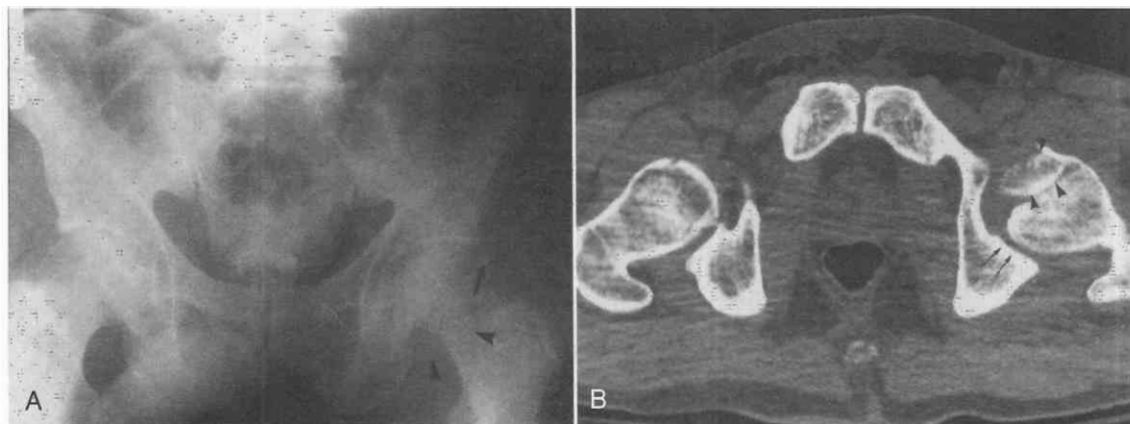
Shearing femoral head osteochondral fracture resulting from posterior hip dislocation in a 39-year-old man after a motor vehicle accident. *A*, Pelvic radiograph after reduction shows a small fragment superolateral to the left hip (*large arrow*); however, large osteochondral femoral head fragment is only vaguely visible (*large arrowheads*). *B*, CT at the lower extent of the acetabulum shows a large osteochondral femoral head fragment (*small arrowheads*) that is rotated 180 degrees, with its articular surface facing the remainder of the femur. The posterior column of the acetabulum is largely intact (*small arrows*). Subcutaneous air is seen anteriorly from associated soft tissue injury.
